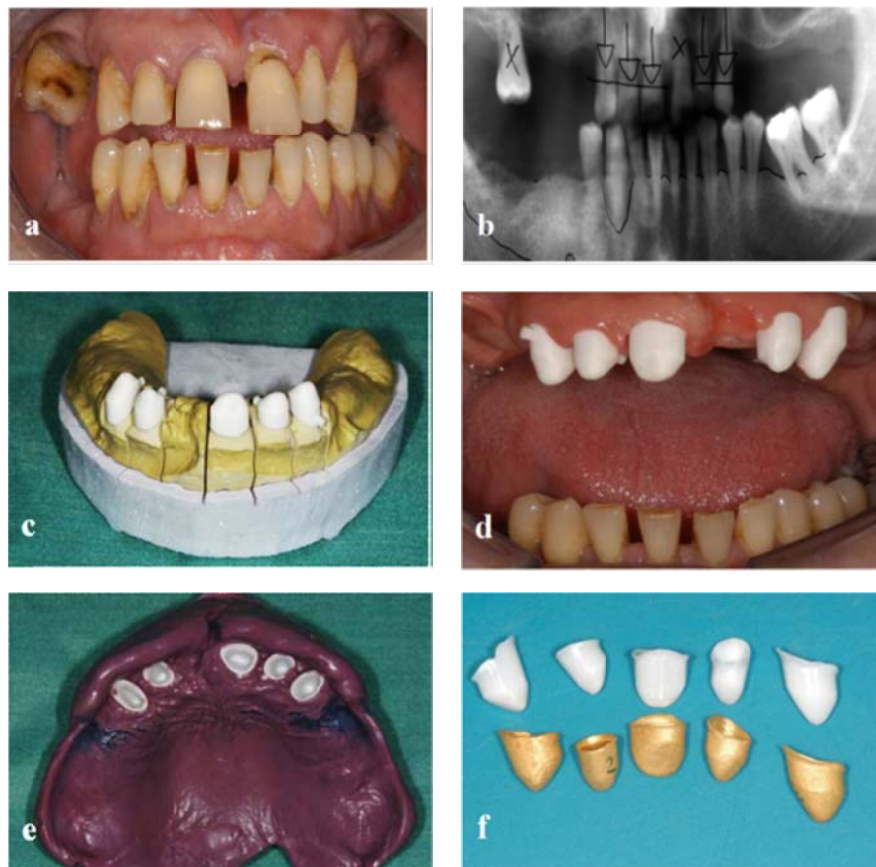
A.G ♂, 55 years. Prosthetic treatment by overdenture on galvanofforming crowns. a) Initial clinical situation b) Orthopan radiograph on patient first visit; c) Primary zirconium oxyde crowns on the work model; d) Checking the oral adaptation of primary crowns; e) Overimpression of primary crowns with individual impression tray and polyether; f) Primary zirconium oxyde crowns and secondary galvanofforming crowns (Archive of the Department of Dental Prosthodontics).
